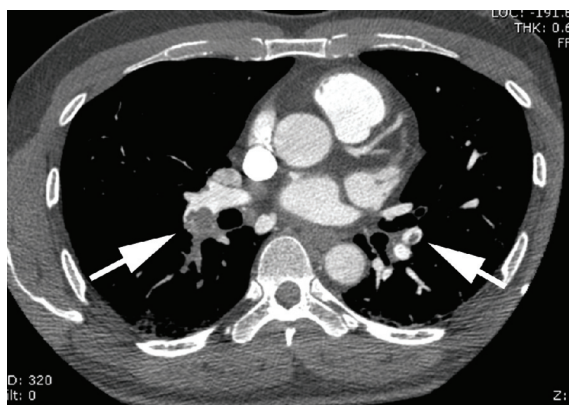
CT pulmonary angiography of 42 year-old man with clinical intermediate probability for pulmonary embolism show filling defect within the superior segmental branch of right and left lower lobe pulmonary arteries (arrows)
